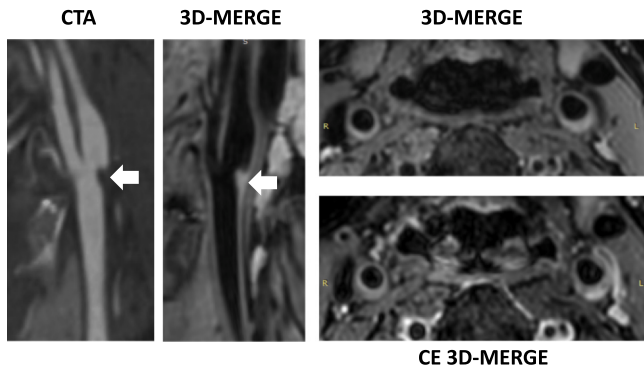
Carotid web: VWI shows a shelf-like protrusion (arrows) into the lumen corroborated by CTA. Note that there are bilateral carotid webs in this patient, seen on the contralateral carotid in the axial reformat. Gadolinium contrast enhancement is seen at the base of the web on the left carotid on post-contrast 3D-MERGE VWI. 3D three-dimensional, 3D-MERGE 3D MSDE prepared rapid gradient echo, MSDE motion-sensitized driven equilibrium, CTA computed tomographic angiography, VWI vessel wall imaging, CE contrast enhanced.
